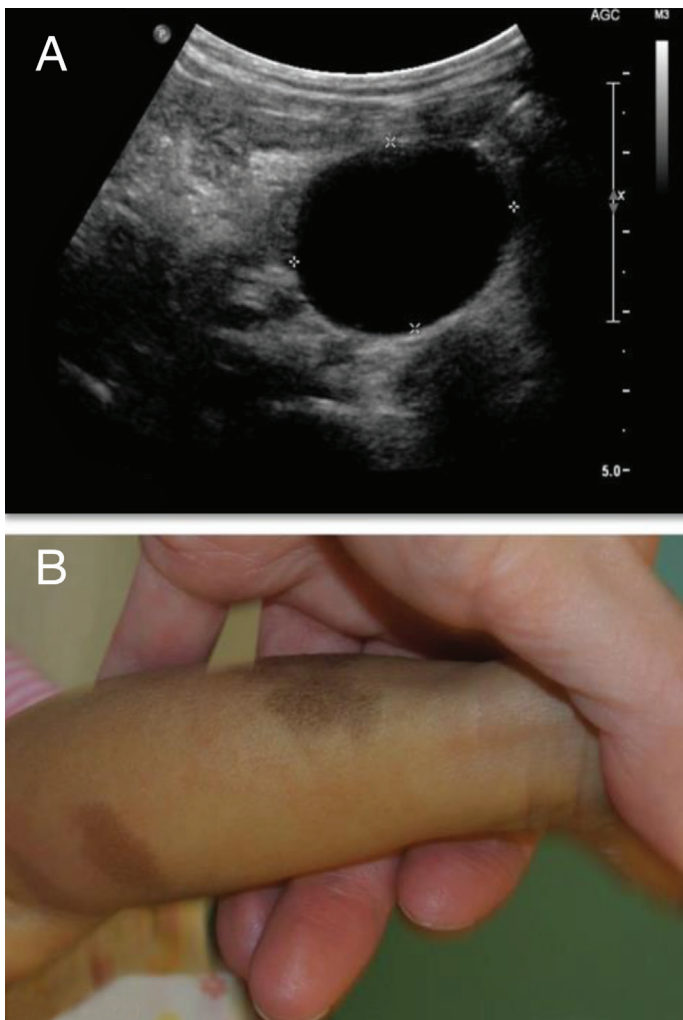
Clinical features suggestive of McCune-Albright syndrome. A) Abdominal ultrasound demonstrating large cystic structure in left ovary. B) Café-au-lait macules present bilaterally on legs and lumbosacral area
